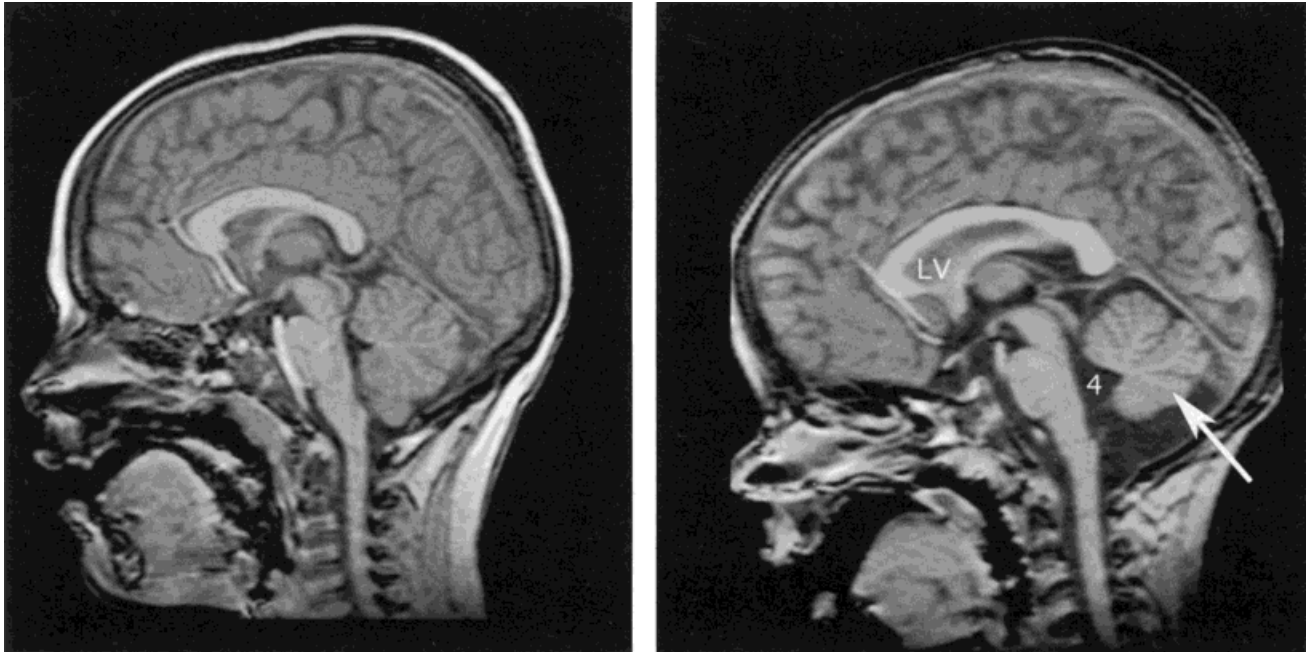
Representative MRI scans. Left: Midsagittal view of *FRAXE* subject 1 (age, 4 years; IQ, 88). Right: Male with *FRAXA* (*FMR1*) mutation (age, 4 years; IQ, 78). Reduction in the posterior cerebellum vermis (arrow), and enlargement in the lateral ventricles (LV), are evident in the *FRAXA* child. These structural differences have previously been observed in studies comparing *FRAXA* subjects to developmentally delayed and normal controls [Reiss et al., 1991, 1995].
